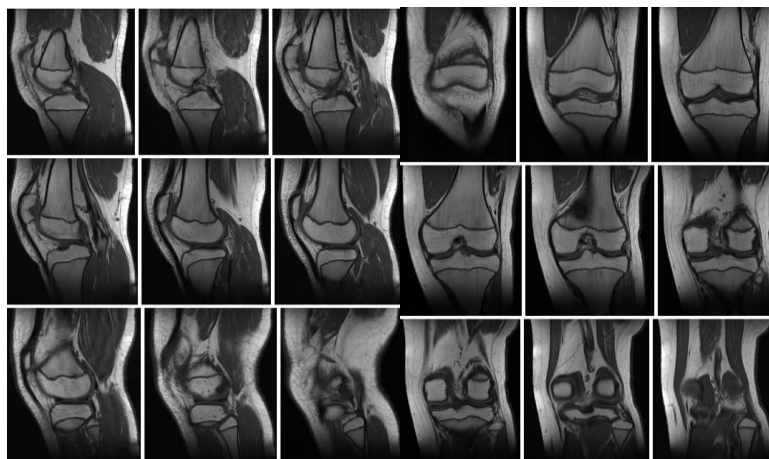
Preoperative MRI. The left knee's T2 and T1 weighted Magnetic Resonance Imaging (MRI) showed an anterior cruciate ligament tear.
